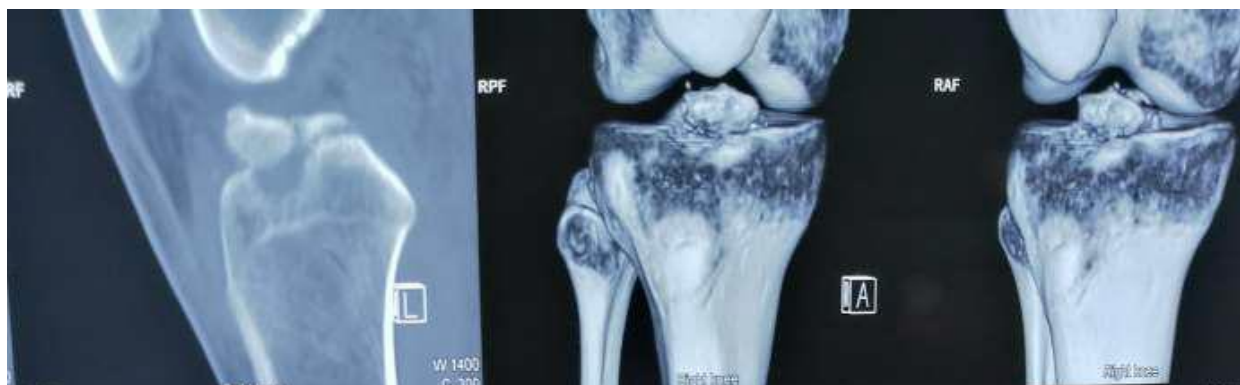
Preoperative CT scans showing tibial spine avulsion fractures
